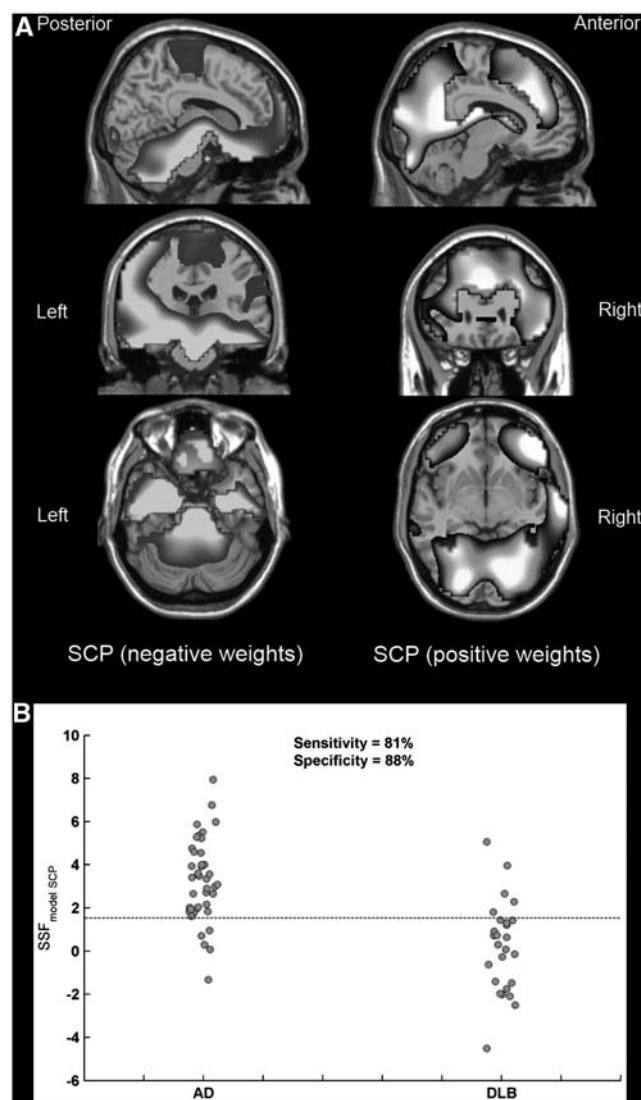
Orthogonal views of the spatial covariance pattern (SCP) that differentiates Alzheimer's disease (AD) and dementia with Lewy bodies (DLB) superimposed onto a magnetic resonance imaging (MRI) template (A). Distribution of $\text{SSF}_{\{\text{model_SCP}\}}$ scores in AD ($n = 40$) and DLB ($n = 26$) (B). Reference line denotes the threshold for 'optimum' DLB sensitivity and AD specificity. SSF, subject scaling factor.
